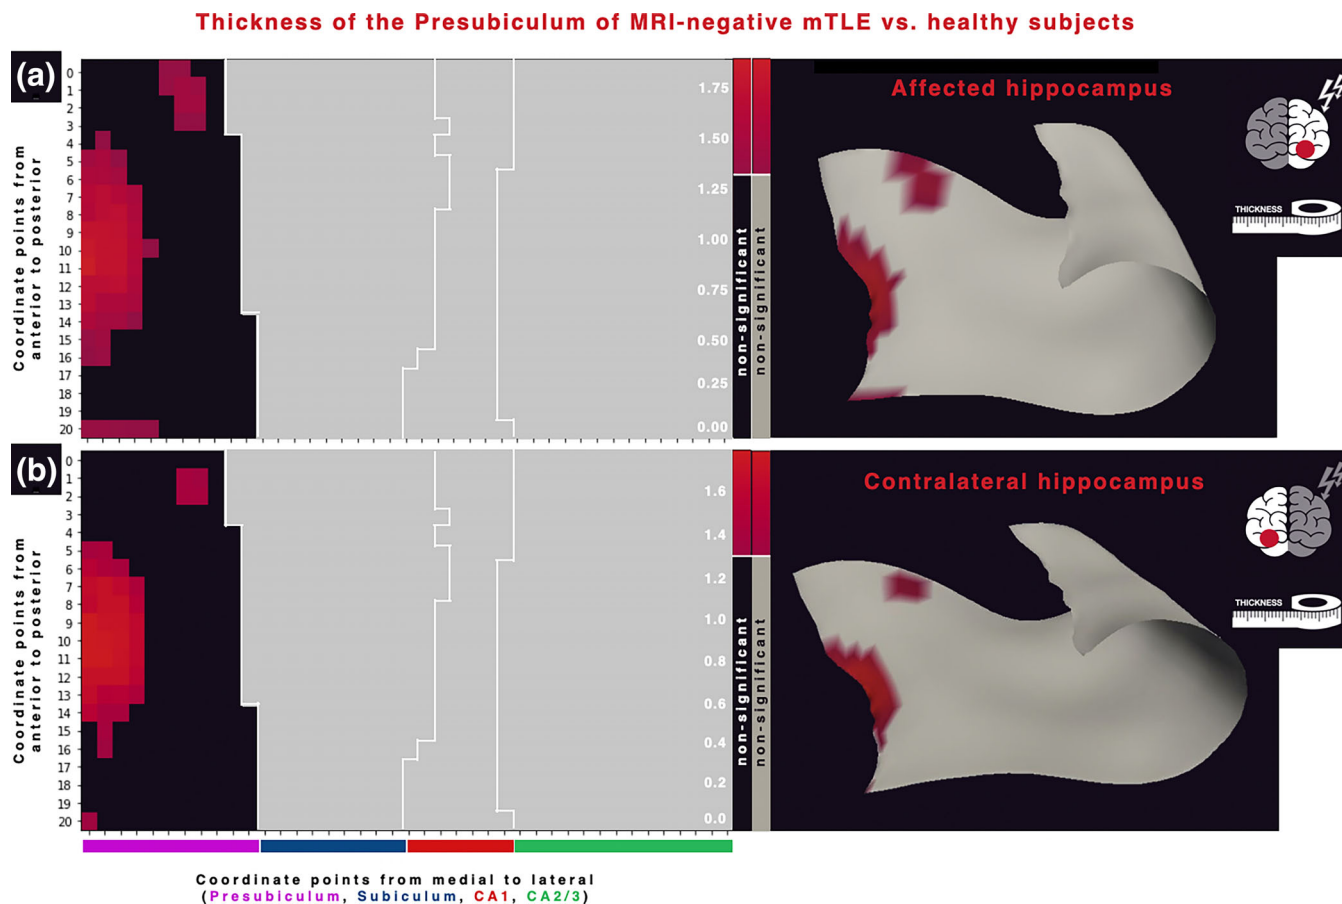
Individuals with MRI-negative mTLE versus healthy subjects: Thickness analysis. (a) Thickness analysis of the affected hippocampus of MRI-negative mTLE versus healthy subjects. (b) Thickness analysis of the contralateral hippocampus of MRI-negative mTLE versus healthy subjects. Left: Negative logarithms of significant p -values mapped along the intrinsic coordinate system of the presubiculum. Non-significant points are shown in black color. White lines: plotted boundaries of subfields, colored bars correspond to subfields. Right: Mapping of the negative logarithms of significant p -values onto the medial surface of a control hippocampus. CA, cornu ammonis; MRI-negative mTLE, individuals with mesial temporal lobe epilepsy and no correlates in magnetic resonance imaging.
